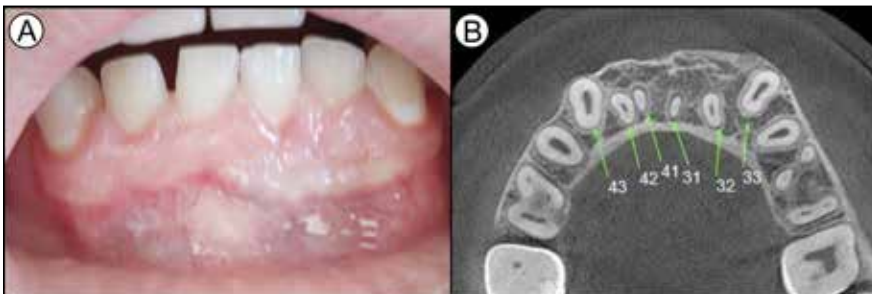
A. Intraoral aspect, 3-year follow-up. B. 3-year follow-up CBCT.
